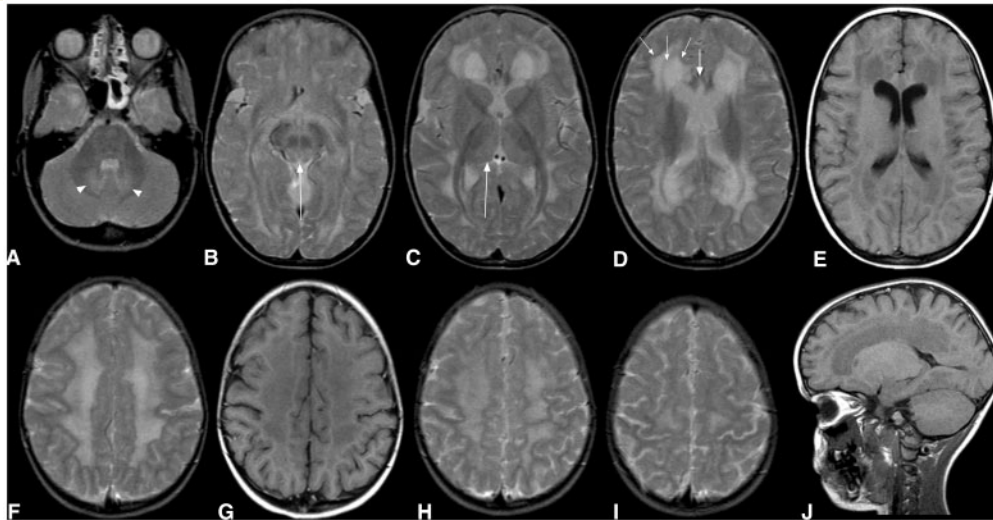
Follow-up MRI (A–D, F, H and I: T₂-weighted; E, G and J: T₁-weighted) of Case 5 (Patient #38) at the age of 9.5 years (i.e. 1 year after the diagnosis has been made and treatment has been started) demonstrates extensive white matter abnormalities persisting in the face of clinical and biochemical improvement since the initial MRI at age 8.5 years (not shown). As in Case 4 (Fig. 4), T₂ hyperintensity is 'bimodal': strongly T₂ hyperintense white matter separated by a rim of near normal signal from less hyperintense more peripheral white matter (unilateral thin arrows). Note involvement of the median corpus callosum (short arrow), of thalamus and midbrain (long arrows), and the dentate nuclei (arrowheads).
